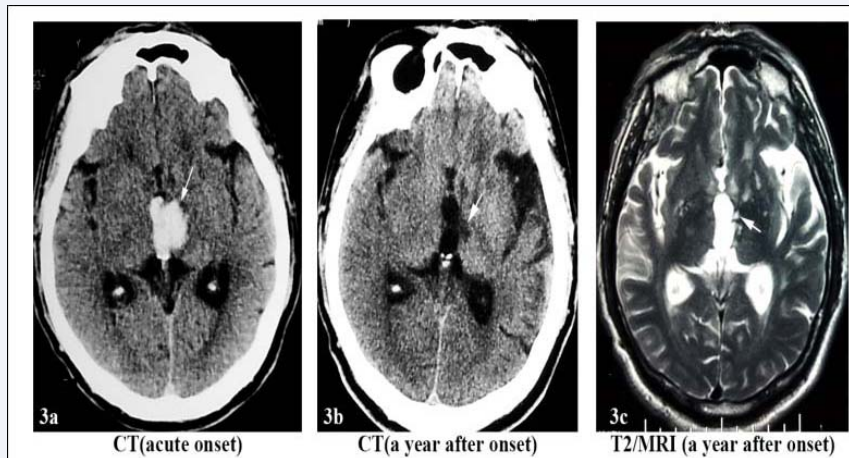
Skull image of case 3; 3a was CT scan on acute onset of thalamic hemorrhage; 3b was CT reexamination and 3c was T2WI /MRI of the patient at 1 year after the onset of ICH. The lesion was hyperintense on T2WI.
